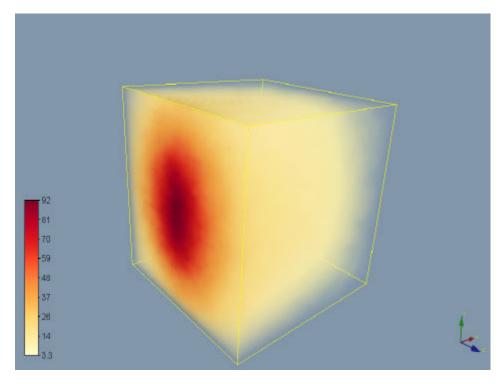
3D Monte Carlo Calculation of the X-ray dose
